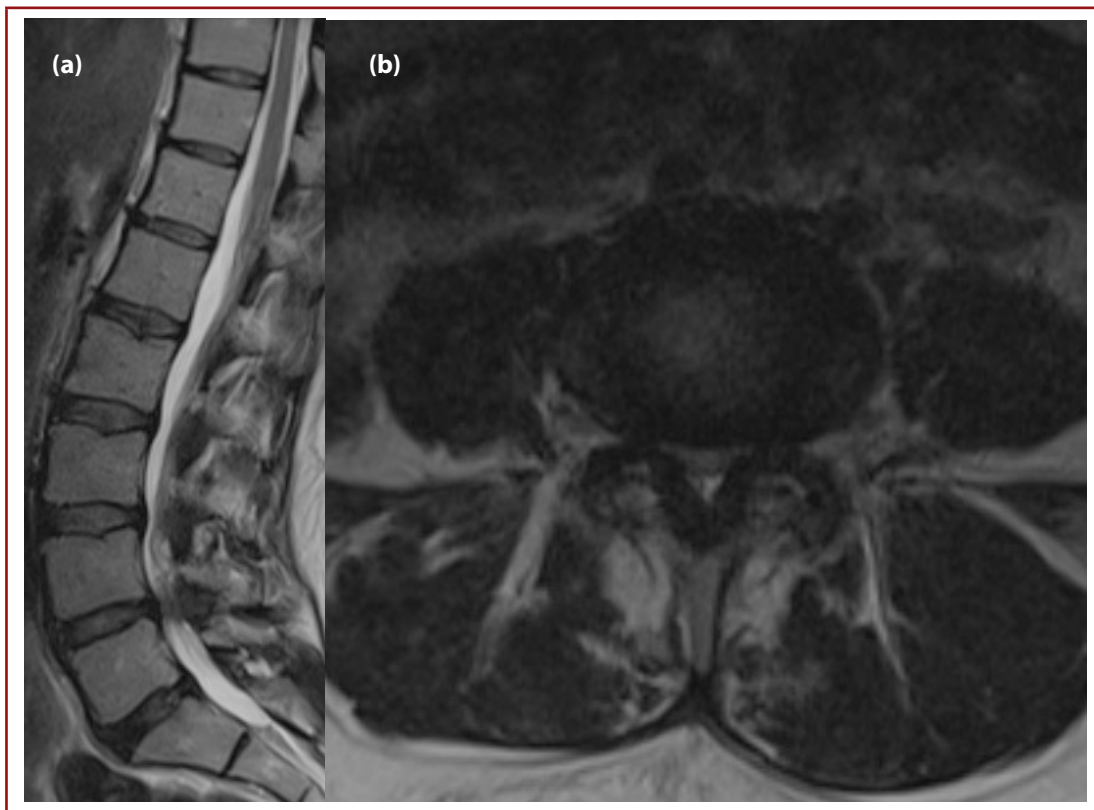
a,b. Preoperative magnetic resonance imaging sagittal image(left) and axial image (right).
